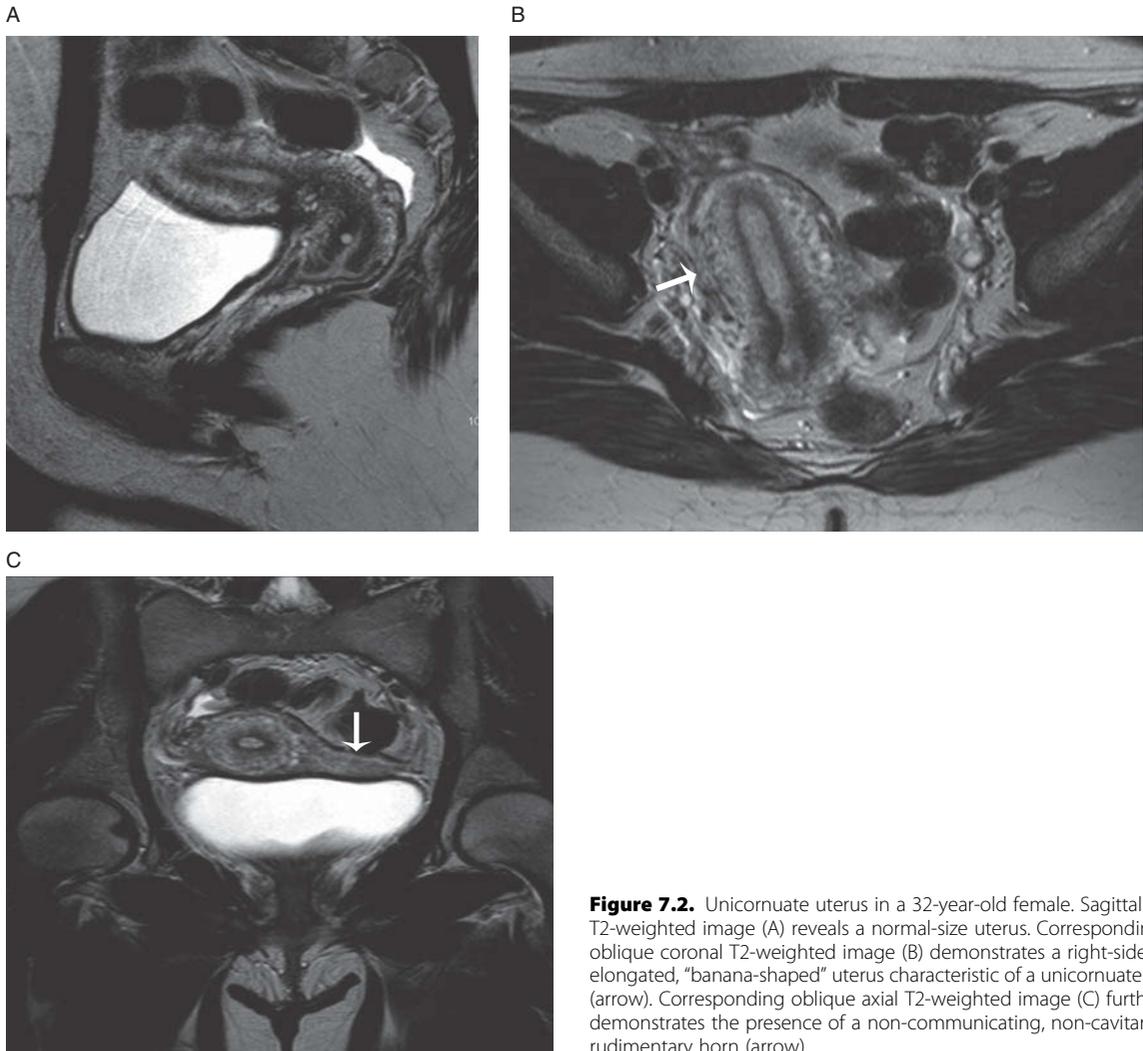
Unicornuate uterus in a 32-year-old female. Sagittal T2-weighted image (A) reveals a normal-size uterus. Corresponding oblique coronal T2-weighted image (B) demonstrates a right-sided, elongated, “banana-shaped” uterus characteristic of a unicornuate uterus (arrow). Corresponding oblique axial T2-weighted image (C) further demonstrates the presence of a non-communicating, non-cavitary left rudimentary horn (arrow).
